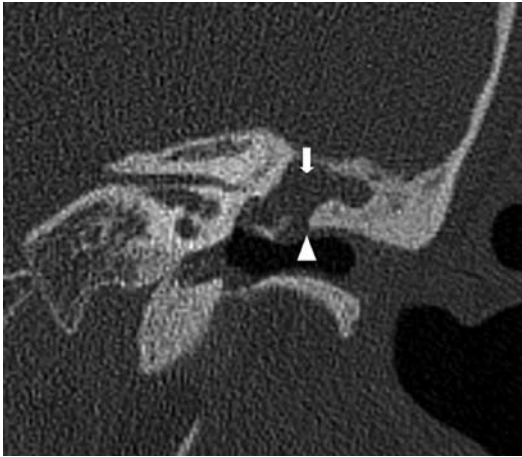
This is a coronal CT image passing through the level of the internal auditory canal in a patient with known middle ear disease. The *epitympanum* is occupied by a soft tissue density (white arrow). The scutum (white arrowhead) is blunted, very much like the tip of a used, unsharpened pencil. Clinical examination and surgical findings confirm the presence of an acquired *cholesteatoma* in the *epitympanum* and *mastoid antrum*.
